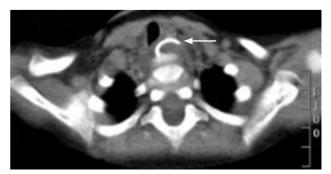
Neck computed tomography.
